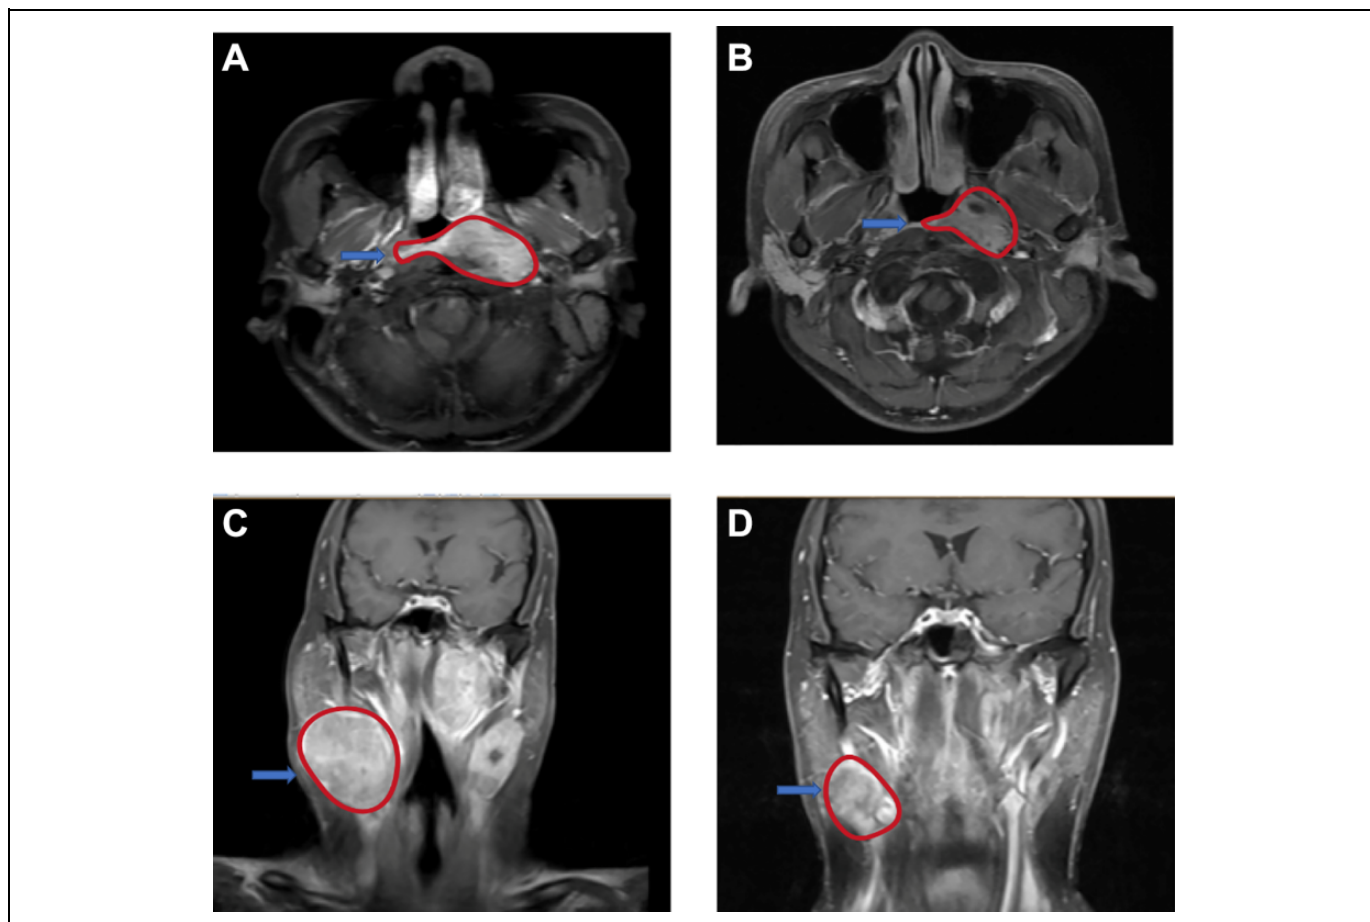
Pre- and post-treatment MRI in patients with residual NPC; red lines represent tumor lesions. (A) MRI showing a local tumor in an NPC patient before radiotherapy; (B) MRI showing local residual tumor within 6 months after RT completion in the same patient in (A) above; (C) MRI showing the lymph node of another NPC patient before RT; (D) MRI showing the lymph node residual tumor within 6 months after RT completion in the same patient as in (C) above. NPC, nasopharyngeal carcinoma; MRI, magnetic resonance imaging; RT, radiotherapy.
